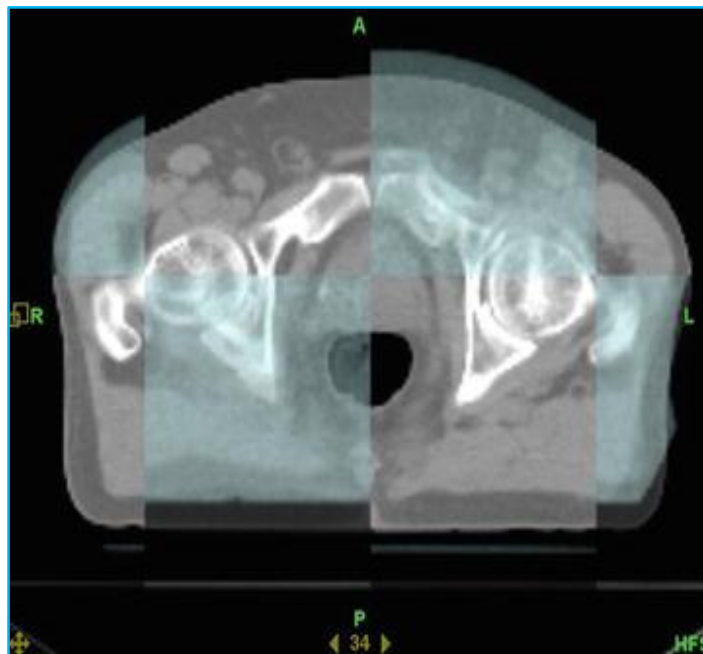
3 Real Daily CT image of tomotherapy machine to get the fit tumor position.
